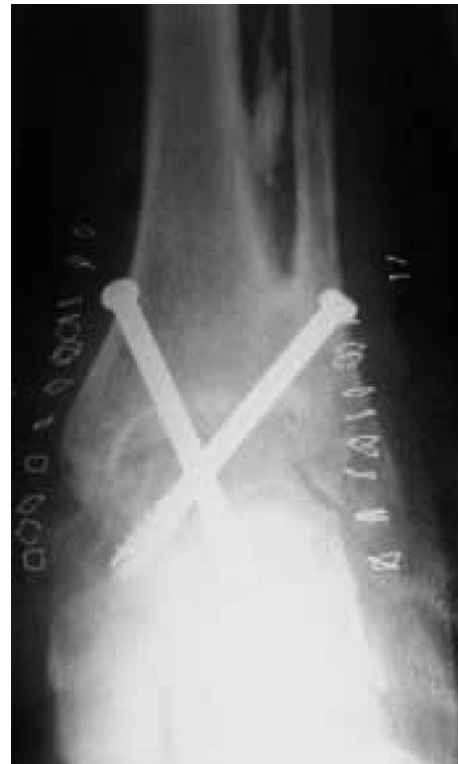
Anterior-posterior weightbearing ankle x-ray, immediate post operative film.
